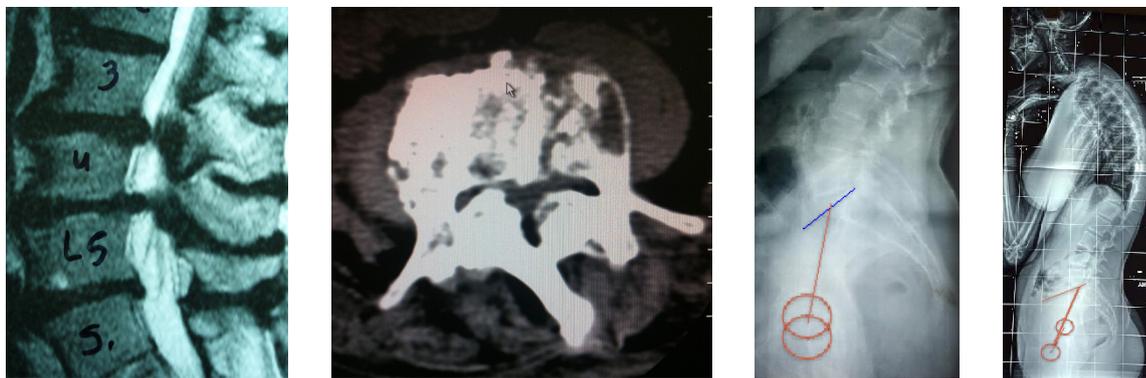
MRI and CT-Scan of LSS. Plain X-Rays are essential especially whole body in upright position to study sagittal balance
